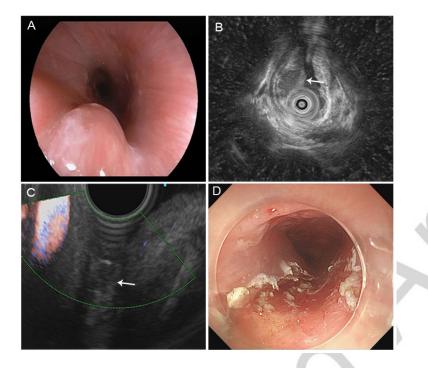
A. Endoscopic view of the submucosal elevated lesion. B. Mini-probe endoscopic ultrasonography (EUS) showing the lesion (arrow) within the submucosal layer, exhibiting a hypoechoic, irregular, and multilocular appearance with well-defined margins. C. Color Doppler demonstrating no intralesional blood flow signals (arrow). D. Endoscopic appearance of the mucosal defect after surgery.
